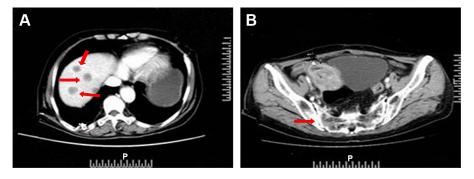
Figure I MRI findings of distant metastasis.
